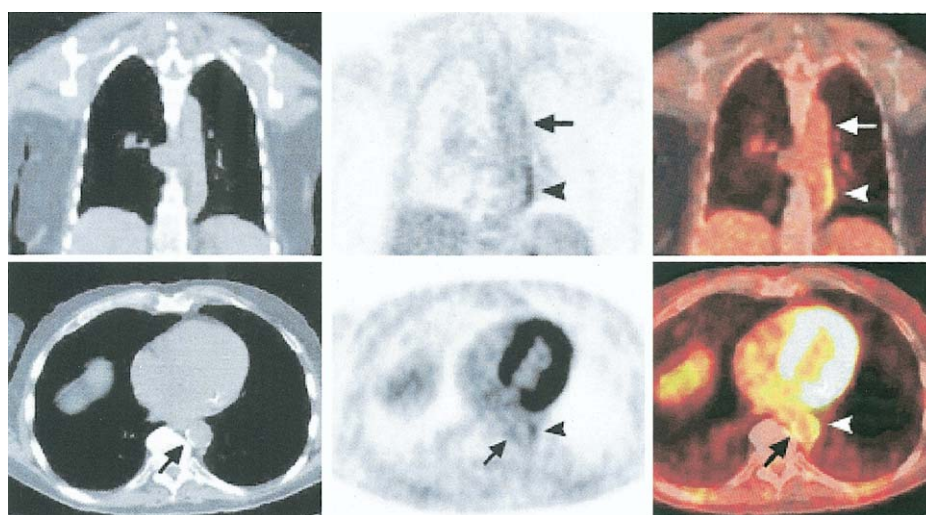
Images obtained by combined positron emission tomography (PET)/computed tomography (CT) machine after administration of fluorine-18-labeled deoxyglucose (FDG) in patients with aortic atheroma. Top row: coronal CT (left), FDG-PET (middle), and fused (right) images. There is no calcium present in the aortic wall on CT. On the PET and fused images grade 1 (arrows) and grade 3 (arrowheads), FDG uptake can be seen in the aortic wall. Bottom row: transaxial CT (left), FDG-PET (middle), and fused (right) images. The CT image shows marked calcification present on the medial side of the descending aorta (arrow), which on the FDG-PET and fused images demonstrates grade 1 FDG uptake (arrows) indicating mild inflammation. Grade 3 FDG uptake is also seen on the lateral side of descending aorta (arrowheads) indicating a higher level of inflammation in this segment of non-calcified vessel wall. Modified, with permission, from Tatsumi *et al.* (42).
